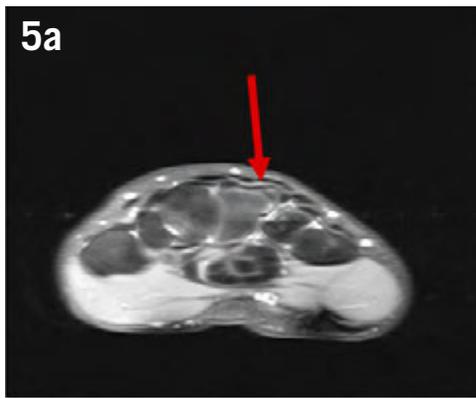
Professional golfer with dorsal wrist pain. (a) demonstrated typical fluid sensitive fat saturated MR appearances of dorsal prominence of the distal capitate in keeping with carpal boss formation. There is bone and soft-tissue oedema centred around an undisplaced transverse fracture (red arrow) of this carpal boss. (b) is a surface rendered CT reformat of the same golfer demonstrating the carpal boss and fracture (red arrow).
